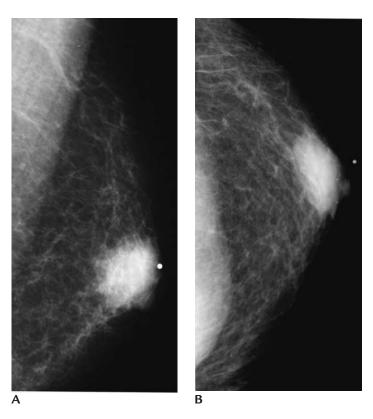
Nodular gynecomastia. (A) Mediolateral oblique and (B) craniocaudal views, left breast. Round area of increased density in the subareolar area, metallic BB used to mark area of clinical concern. Prominent pectoral muscle common in male patients. On ultrasound (not shown) no focal abnormality is seen.
